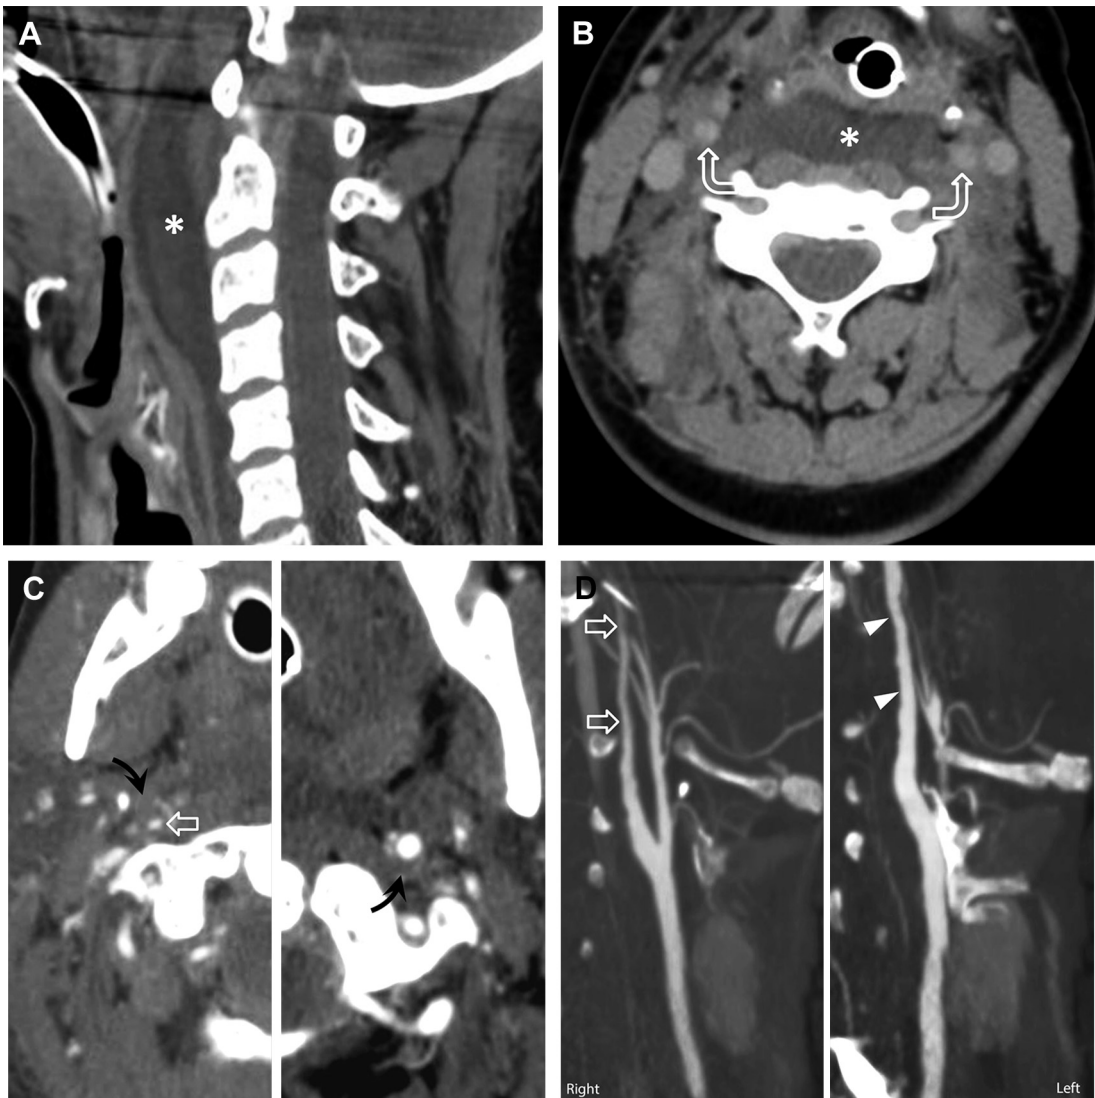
Bilateral ICA dissections with “string” signs. Sagittal (A) and axial (B) CT images demonstrate a large retropharyngeal hematoma (*asterisk*), which extends laterally to the carotid spaces (*curved open arrows*), suggesting the possibility of traumatic BCI and the need for a CTA. (C) Axial and (D) bilateral sagittal CTA images reveal intramural hematoma (*curved arrows*) causing severe right (Denver grade 2) (*open arrows*) and mild left (Denver grade 1) (*arrowheads*) luminal compromise (string sign).
